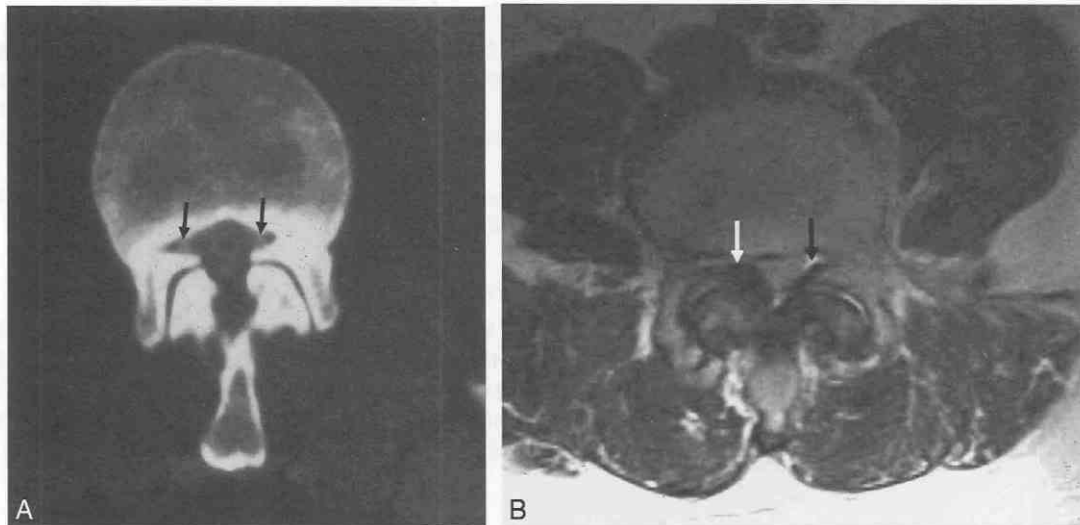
A, Lateral recess stenosis. CT scan shows preexisting nerve roots (arrows) within tiny lateral recesses. This patient with achondroplasia had nondegenerative congenital spinal stenosis. Compare with normal lateral recesses in Figure 22-4E. B, T2-weighted scan, same patient as in Figure 22-11C. The hypertrophied ligamentum flavum has obliterated the right lateral recess (white arrow). The left lateral recess (black arrow) is also narrowed by the hypertrophied facet, but some epidural fat can still be seen.
